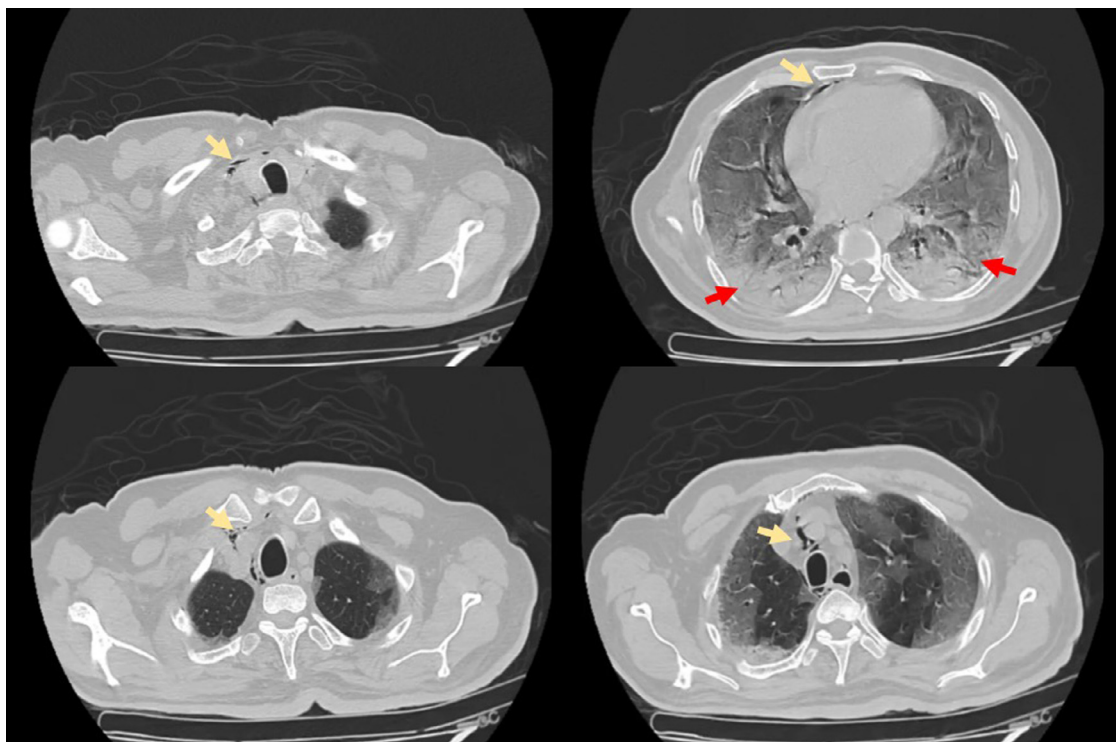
Chest CT of Patient One showing diffuse ground-glass attenuation, consolidations in the posterior basal segments of the lower lobes (red arrows), and SPM (yellow arrows). (Color version of figure is available online.)
